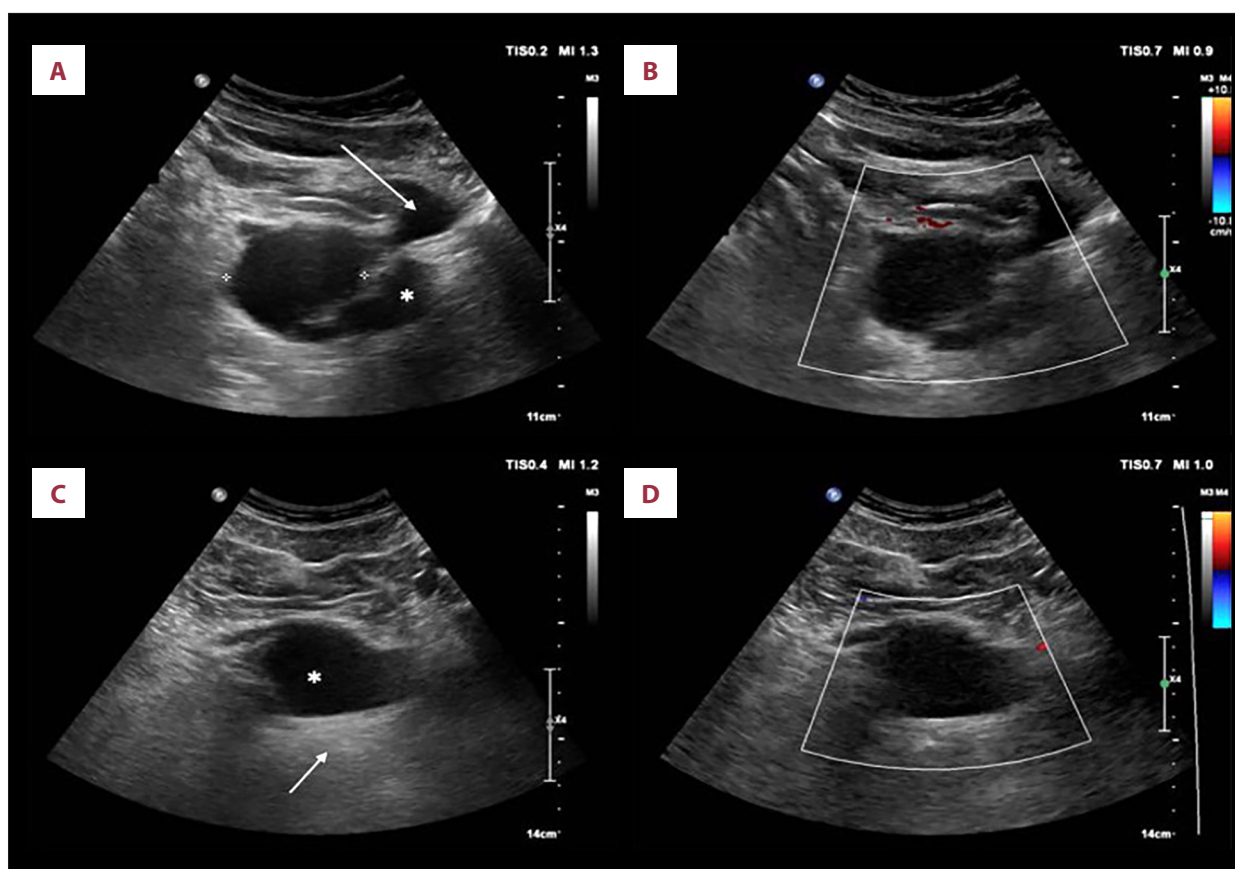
(A-D) A sagittal ultrasound of the patient's pelvis reveals a thin-walled cystic lesion (arrow) behind the bladder, in the region of the left seminal vesicle. Doppler imaging reveals no blood flow within the cyst wall, and its contents are uniformly fluid. These findings are characteristic of a seminal vesicle cyst associated with Zinner syndrome.
